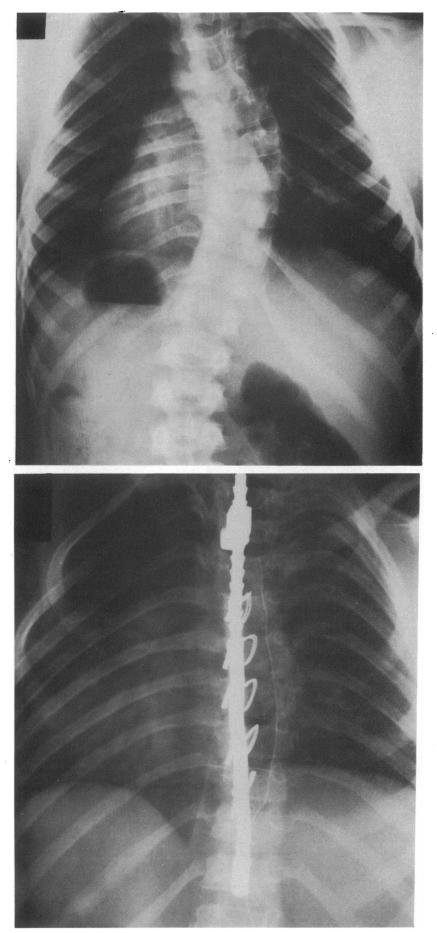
(a) PA radiograph of a patient with idiopathic thoracic scoliosis before surgery. (b) PA radiograph of the same patient after concave kyphotic rodding and concave sublaminar wiring. The deformity has been markedly improved.
